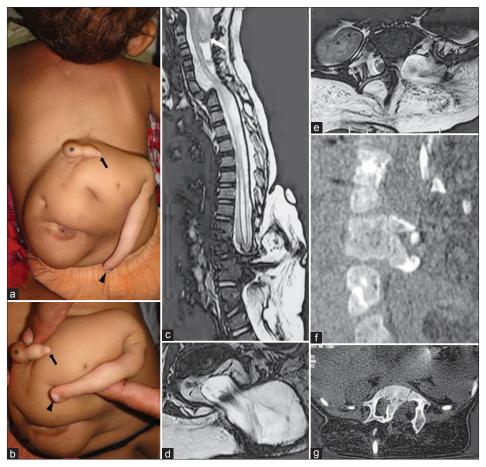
(a and b) A child with midline dorsal mass (arrows) with attached rudimentary genitalia and (arrowheads) finger; (c) spinal MRI and CT scan revealed lipomeningomyelocele sac in the thoracolumbar region; (d) with neural tissue entering into the sac; (c, e-g) type I split cord malformation at T10-11 level; (c) long-segment syrinx involving the thoracic cord (white arrow in c); multiple vertebral bony anomalies, and Chiari malformation
